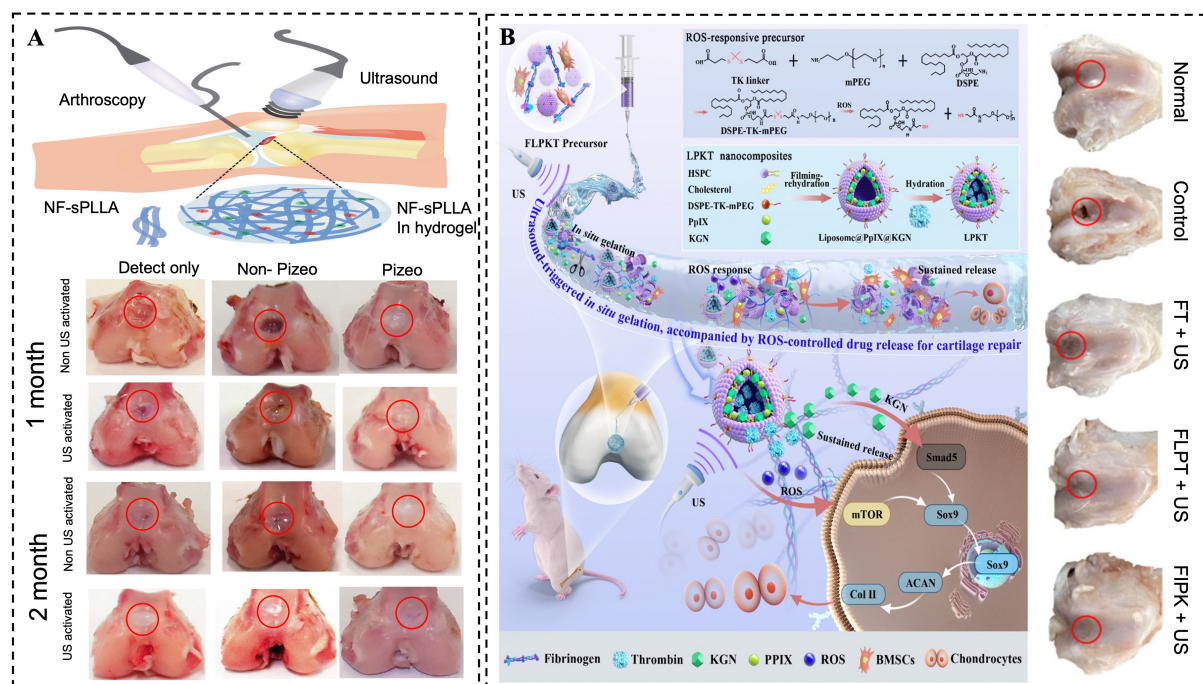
Multifunctional-stimulus responsive systems. (A) A NF-sPLLA hydrogels system based on a piezoelectric and ultrasound stimulus-response^[108]. (Open access). (B) A LPKT hydrogels system based on an ultrasound, enzyme and ROS stimulus-response. (Reproduced with permission^[109]. Copyright 2023, *Materials Horizons*).
